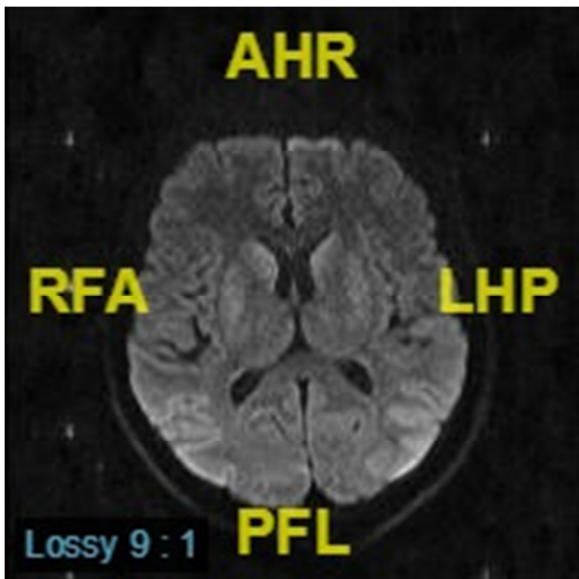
Cranial DWI MRI obtained 5 days after a cardiac arrest showing signal enhancements in cerebellum, bilateral basal ganglia, parietookipital cortex
